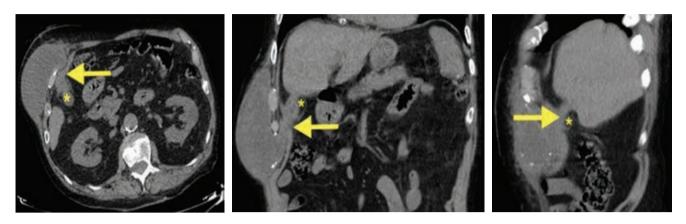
An abdominal CT scan showing complicated chronic calculous cholecystitis (asterisk) in continuation with an abscess in the abdominal wall and a fistula to the skin surface (arrow).
